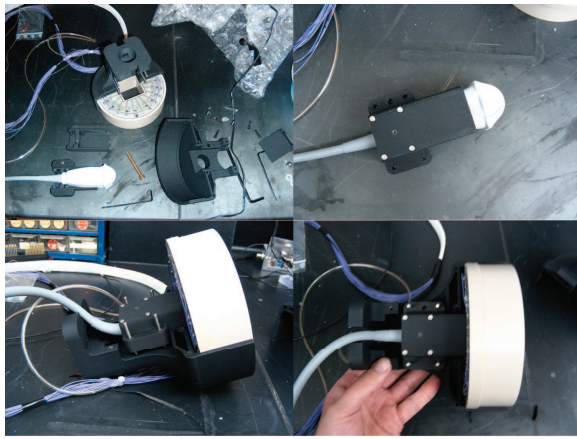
Details of end-effector assembly. Ultrasound probe is mounted on a 1 DOF stage for alignment. HIFU probe is encapsulated with epoxy for waterproofing and protection against environmental debris.
